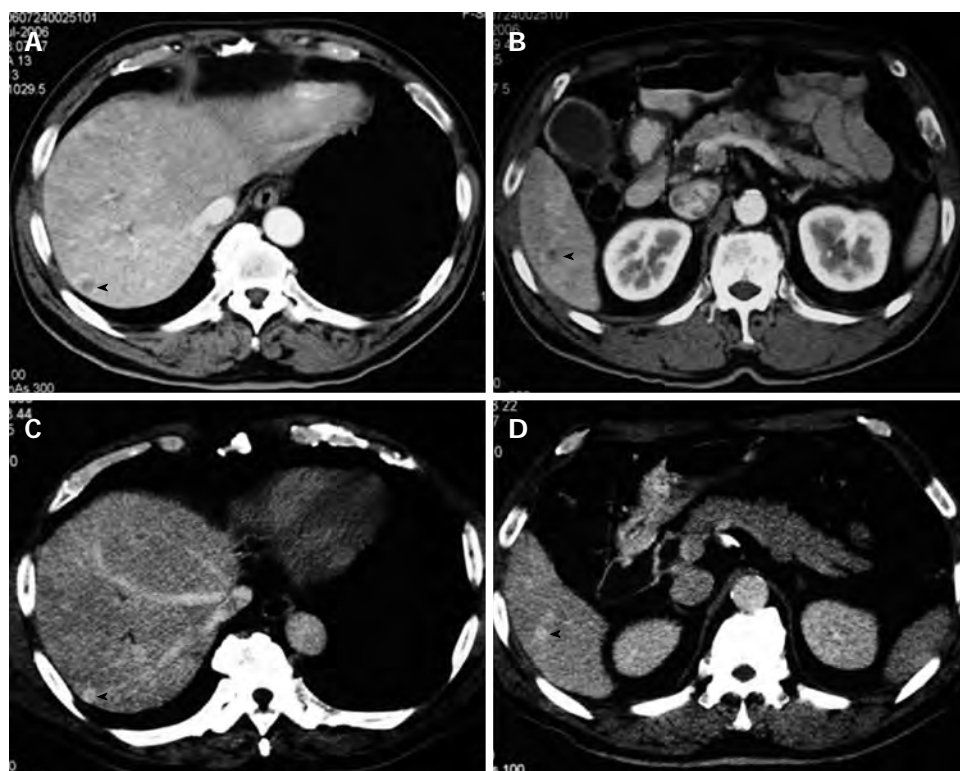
Abdominal computed tomography and computed tomography angiography images at two different levels are shown. A: Computed tomography (CT) showed a low-density mass measuring 8 mm in diameter located in segment 7 of the liver (arrowhead); B: CT showed a low-density mass measuring 8 mm in diameter in segment 6 (arrowhead); C: Computed tomography angiography (CTA) demonstrated an enhancing mass lesion at the same location as in Figure 2A (arrowhead); D: CTA demonstrated an enhancing mass lesion at the same location as in Figure 2B (arrowhead).
